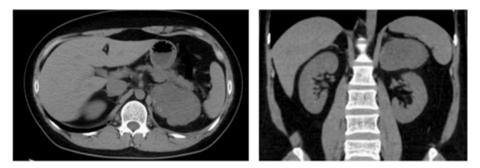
Computed tomography revealed a left retroperitoneal mass measuring 15 x 9 \times 6 cm.
